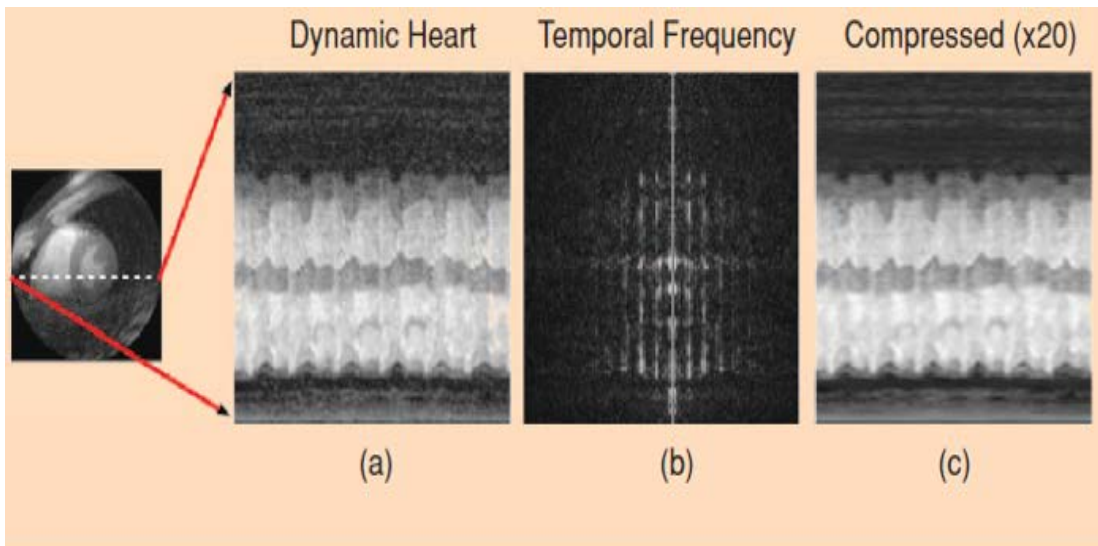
Transform sparsity of MR images. (a) Fully sampled images have sparse representations in an appropriate (b) transform domain. Only a small number of high-value coefficients are preserved while all others are set to zero; the transform is inverted forming a (c) reconstructed image. With kind permission of (Lustig et al., 2008).
